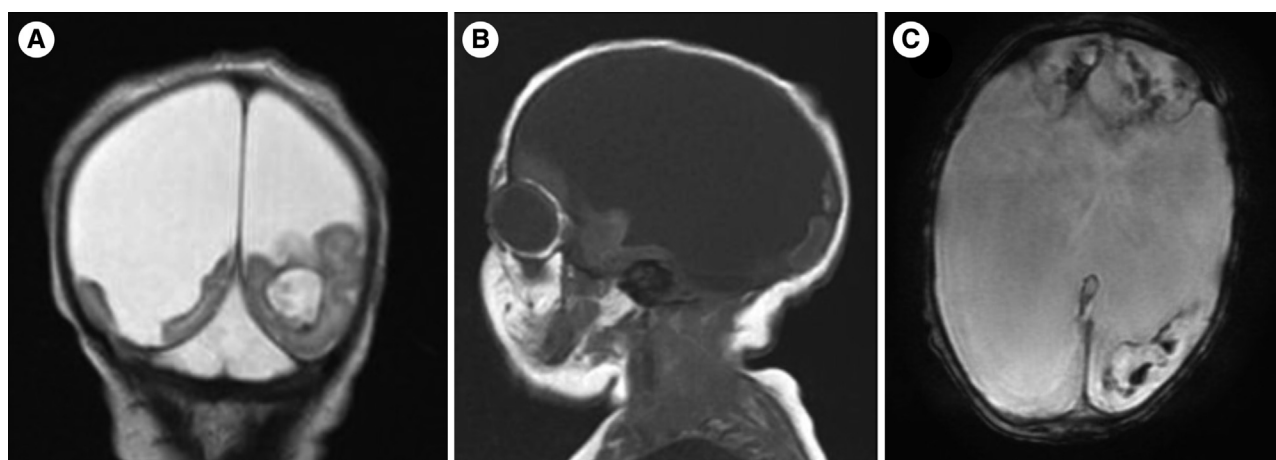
Noncontrast brain MRI with coronal fast spin echo T2-weighted (A) and sagittal T1-weighted (B) imaging demonstrate severe cystic encephalomalacia and minimal residual brain parenchyma. Susceptibility weighted imaging (C) suggests evidence of hemorrhagic infarcts.
